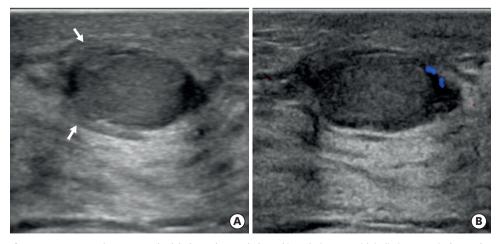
Transverse ultrasonography (A) showed an oval-shaped isoechoic mass with indistinct margin (arrows). Color Doppler image of the mass (B) showed peripheral vascularity.
